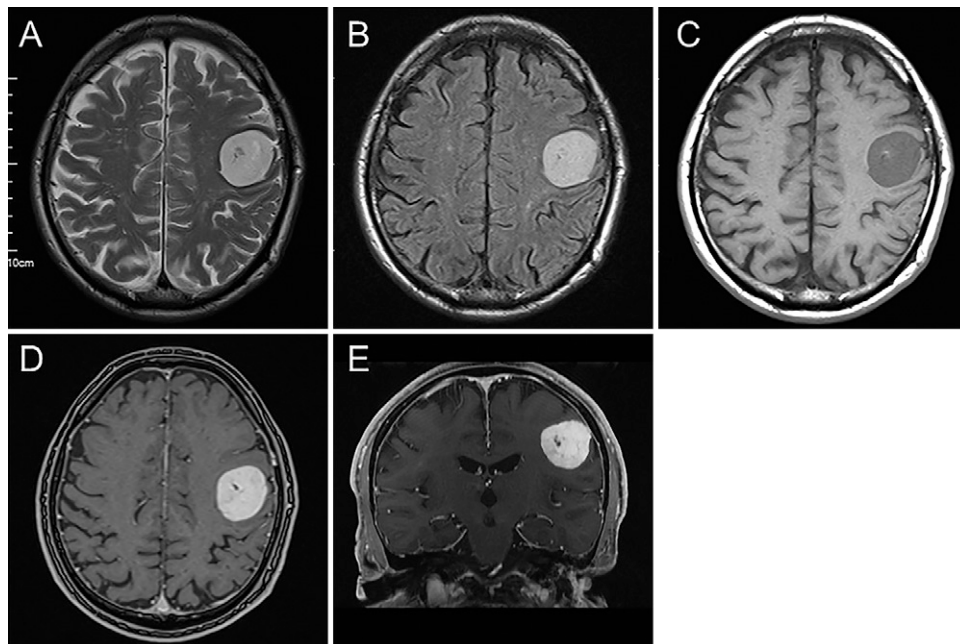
Preoperative axial T2- (A), FLAIR T1- (B), T1-weighted (C) MRI with gadolinium enhancement (D), and coronal T1-weighted MRI with gadolinium enhancement (E) showing a mass lesion in the left frontal lobe with no peritumoral edema. The lesion was homogeneously enhanced and not connected to the skull base. FLAIR = fluid attenuated inversion recovery.
